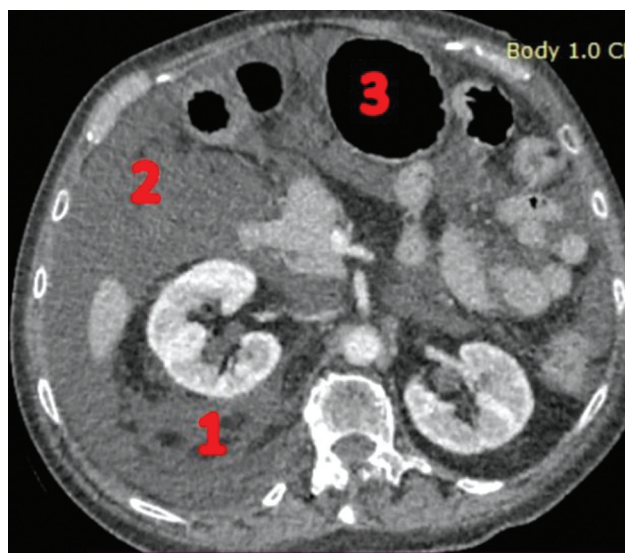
CT scan of the abdominal organs after surgery: 1 - edema of the retroperitoneal perirenal tissue on the right, 2 - free fluid in the abdominal cavity, 3 - stomach swollen with gas
